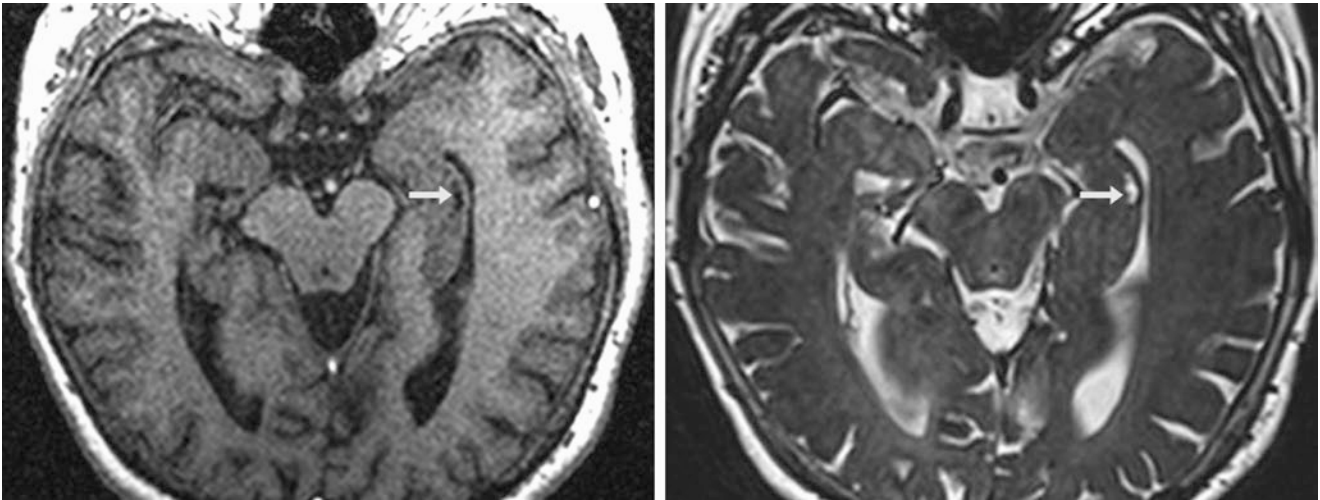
A 78 year old had an incidental finding of a string of left hippocampal cysts (*arrows*) on thin 1-mm axial T1WI (*left*) and T2WI (*right*). The MRI was obtained as stereotactic planning for deep brain stimulator placement
